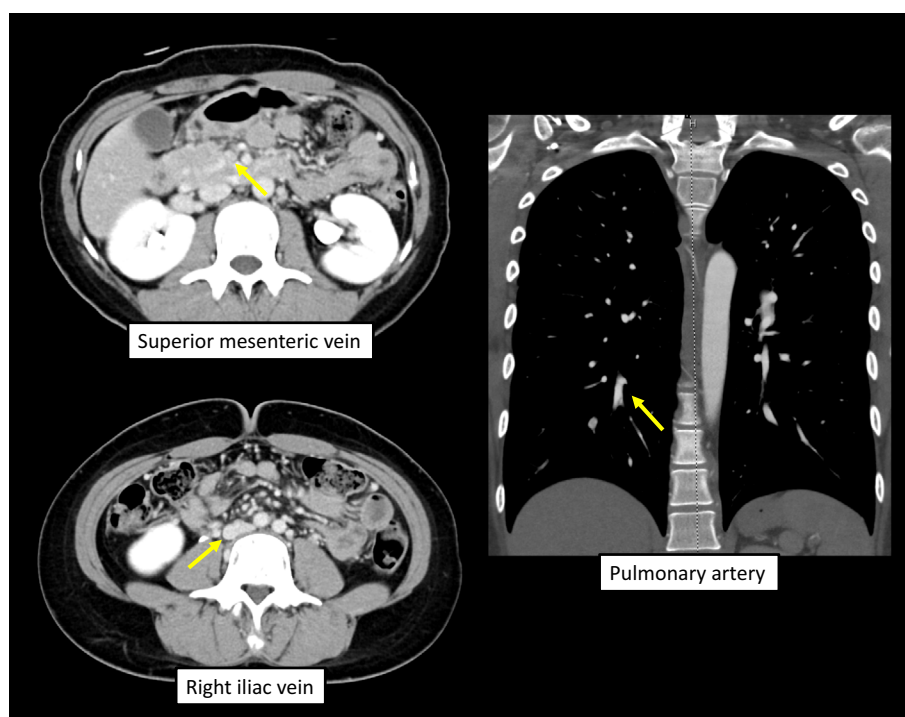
Follow-up CECT axial image at 56 days after discharge shows disappearance of the thrombi in the superior mesenteric vein and common iliac vein. CECT coronal image obtained the same day shows disappearance of the thrombus in the right inferior pulmonary artery. Yellow arrows show sites where previously large thrombi existed. CECT: contrast-enhanced computed tomography
